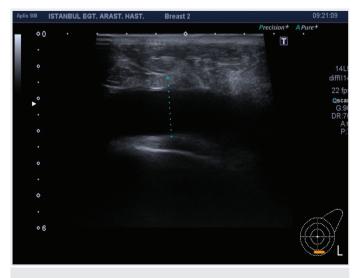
A 53-year-old patient one year after surgery with ultrasonography image showing an anechoic seroma formation in the lower quadrant
